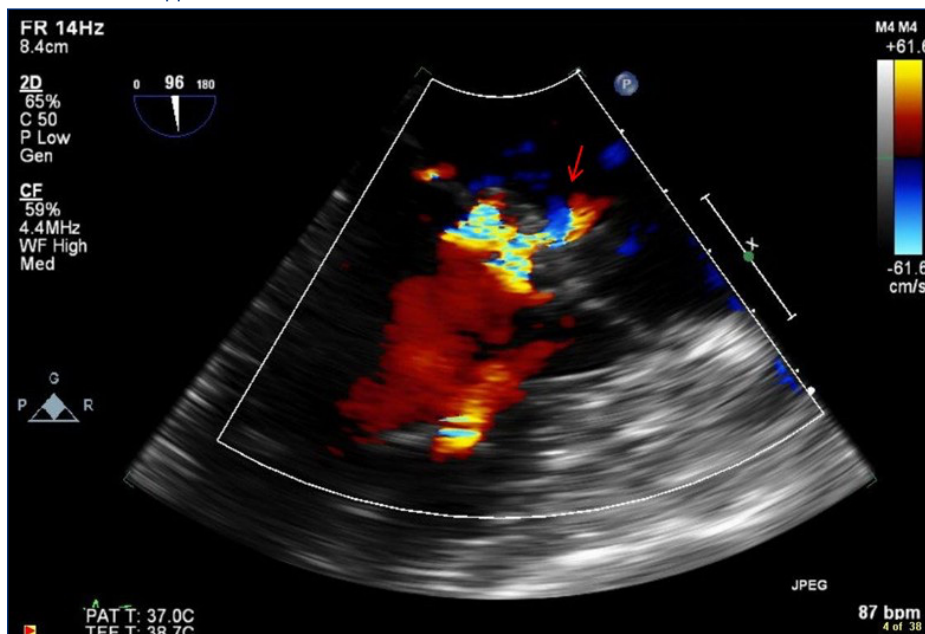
Trans-esophageal echocardiographic image of regurgitant flow (red arrow) across the mitral valve on color doppler view.
